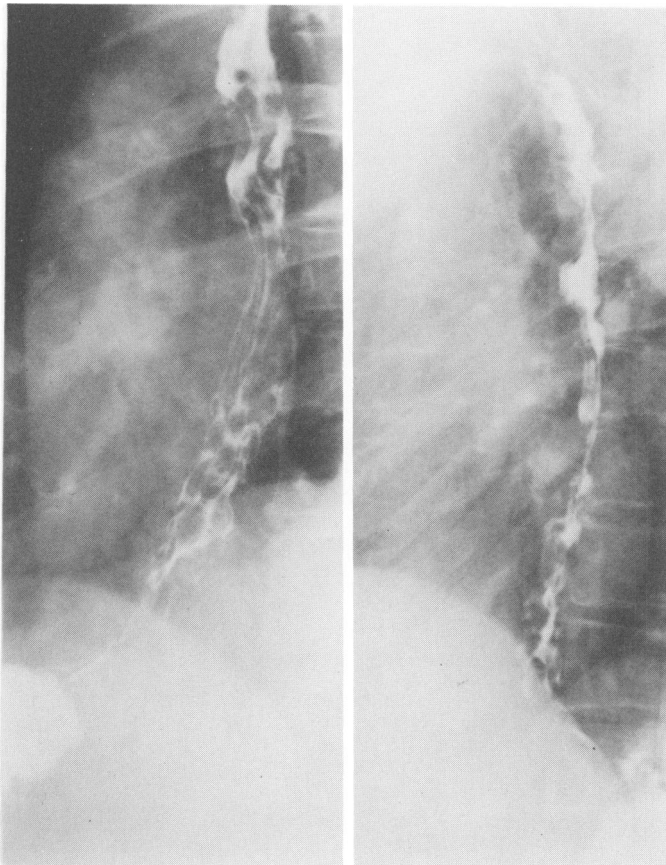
X-ray of the esophagus before sclerosing therapy in a chronic case, *i.e.* the interval free of hemorrhage.
